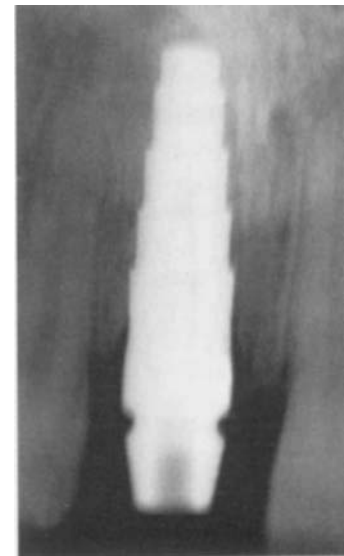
■ Radiograph of test seating confirms correctness.
